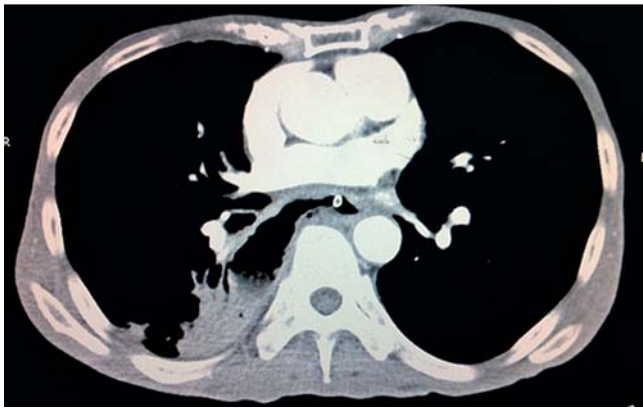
Computed tomography (CT) scan showing the esophagopleural fistula.
